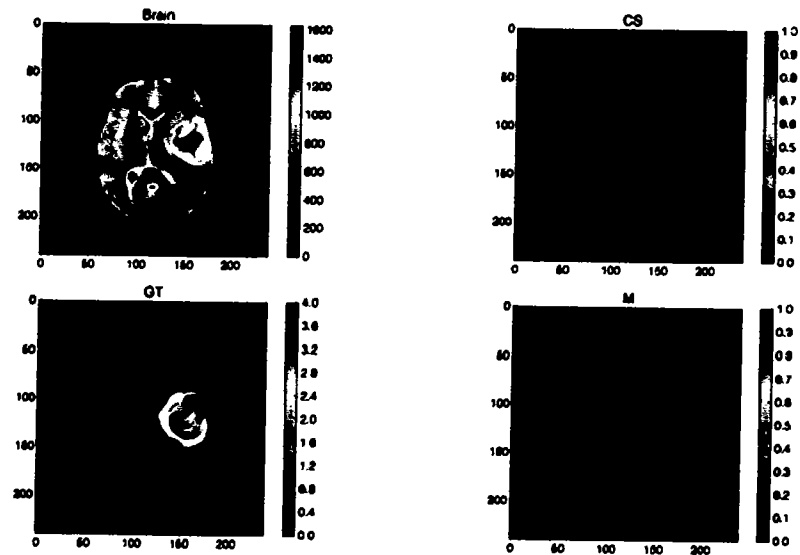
T2-weighted MRI confidence surface
